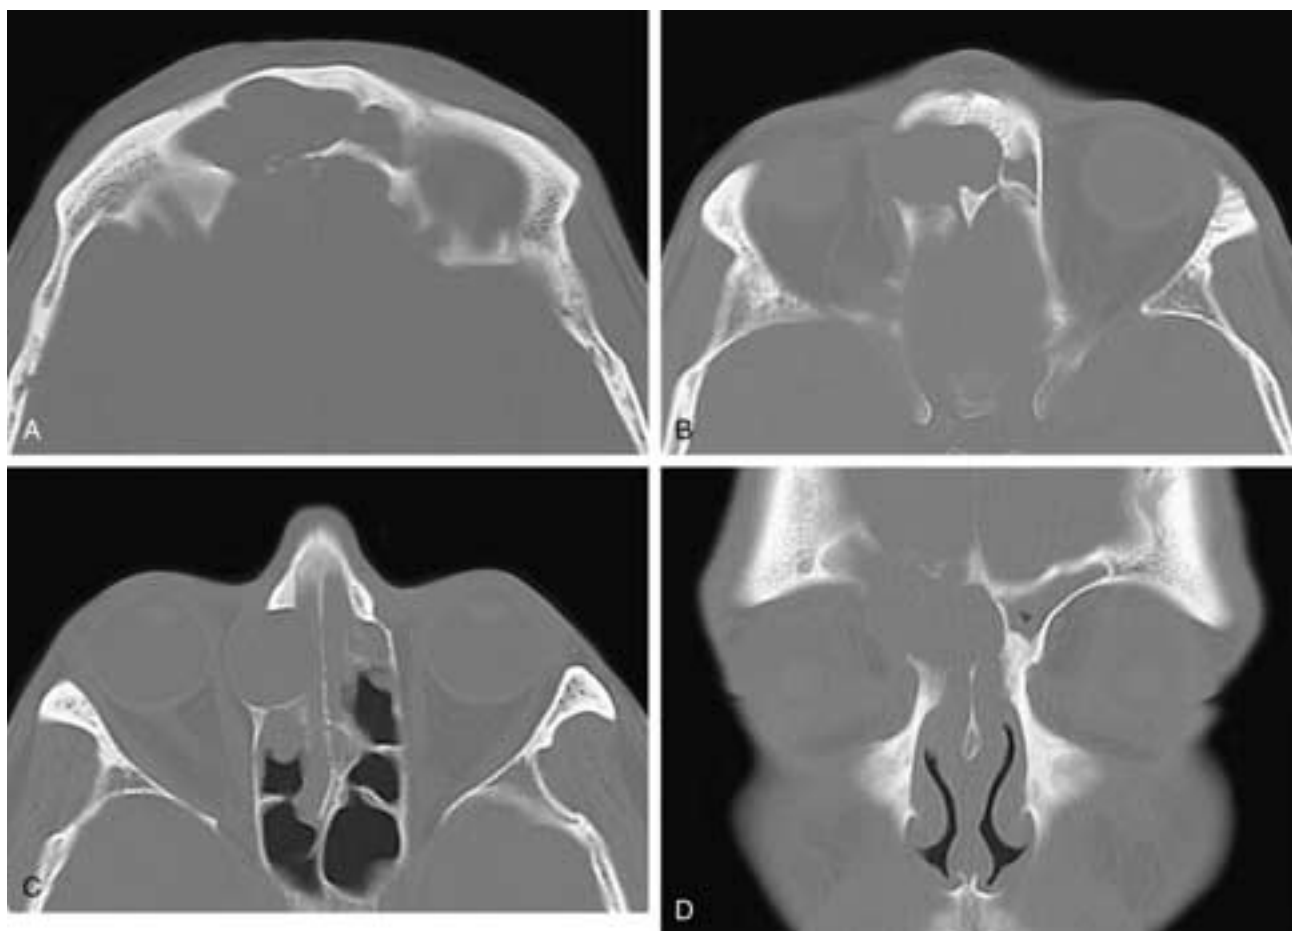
Serial axial CT scans from cranial (A) to caudal (C) and a coronal CT scan (D) show an expansile mass in the right frontal and ethmoid complex. There are areas of marked thinning of the surrounding bone. This patient had a right frontoethmoid mucocoele.
